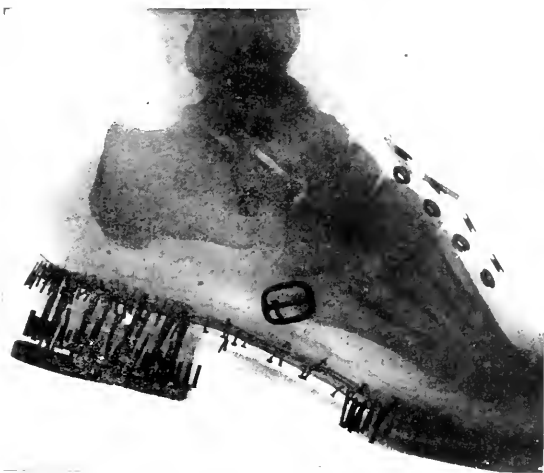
Radiograph of foot in boot taken on ordinary plate.
